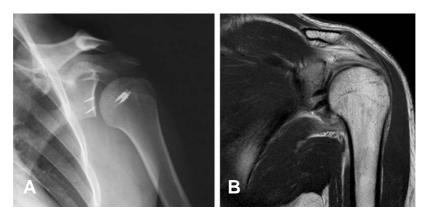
Postoperative 3 month radiographs and follow up MR scans showed complete healing of the capsular tear and Bankart lesion.
